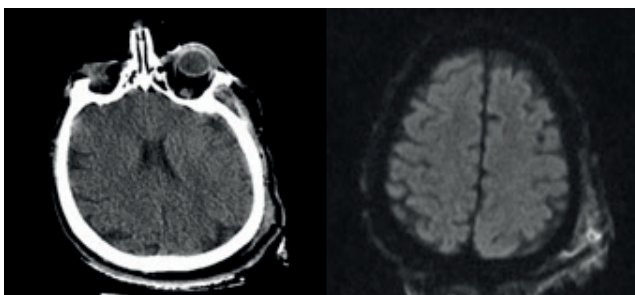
Subcutaneous hematoma in left parietooccipital on brain CT image, intensity thickness increase consistent with post-traumatic hematoma in the subcutaneous of planes in the left parietal in diffusion MR examination
